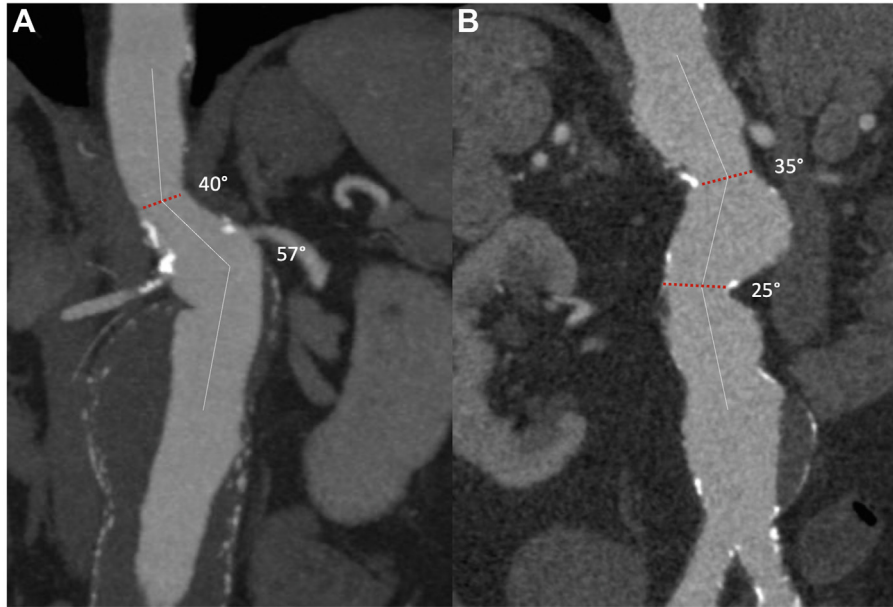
(A) Computed tomography angiography (CTA) multiplanar reconstruction of a pararenal aortic aneurysms (PRAA) with a narrow paravisceral aorta (NPA) (red dotted line) associated with aortic angulation of $>30^\circ$ (white solid line). (B) CTA multiplanar reconstruction of a PRAA with a multifocal NPA (red dotted line) associated with aortic angulation of $>30^\circ$ (white solid line).
